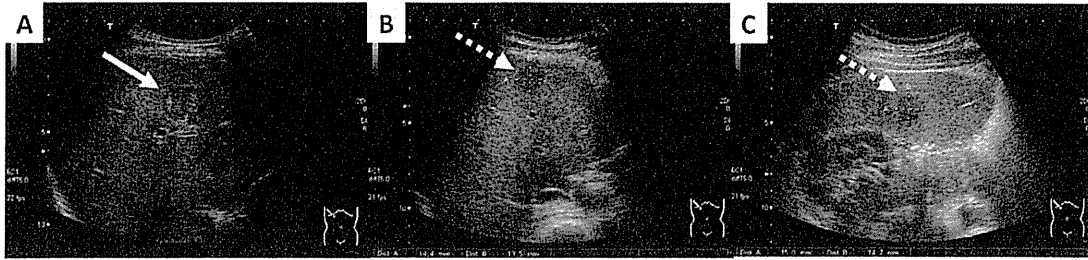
Ultrasonography showing multiple hypoechoic lesions in the liver. The nodule in segment 5 was diagnosed pathologically as cHCC-CC, which was more sharply-margined than other nodules, with mosaic pattern internal echo (Panel A, arrow). The other lesions were nonneoplastic (Panel B and C, dotted arrow).
